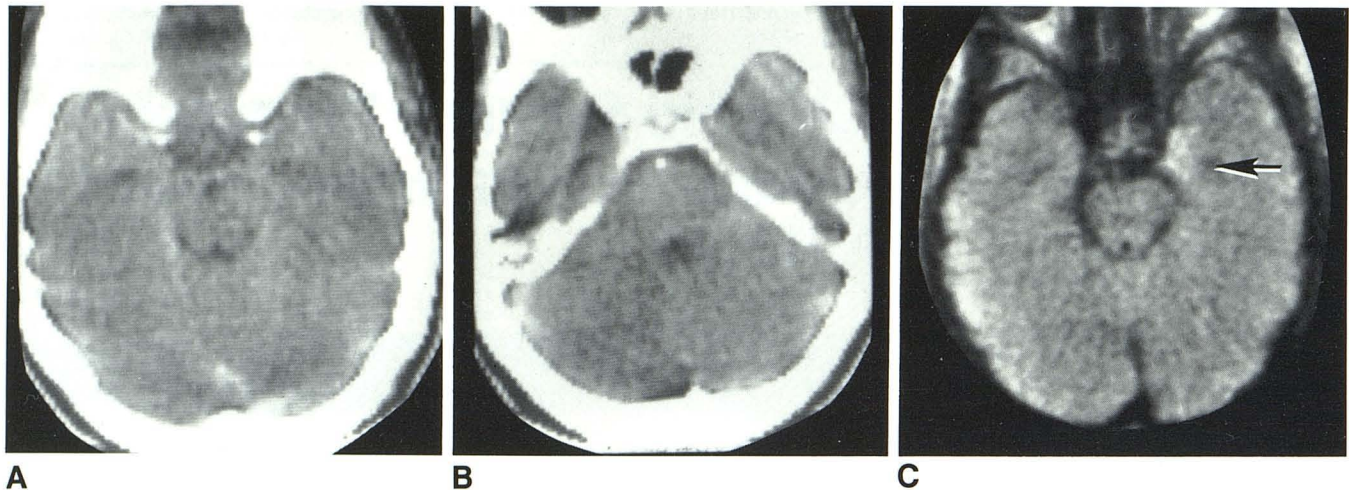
Case 1. A and B, Contiguous 8-mm-thick postinfusion CT scans. Absence of temporal lobe abnormality. C, SE 1080/80 image. Slightly dilated temporal horn (arrow) and area of high signal intensity in uncus medially.
